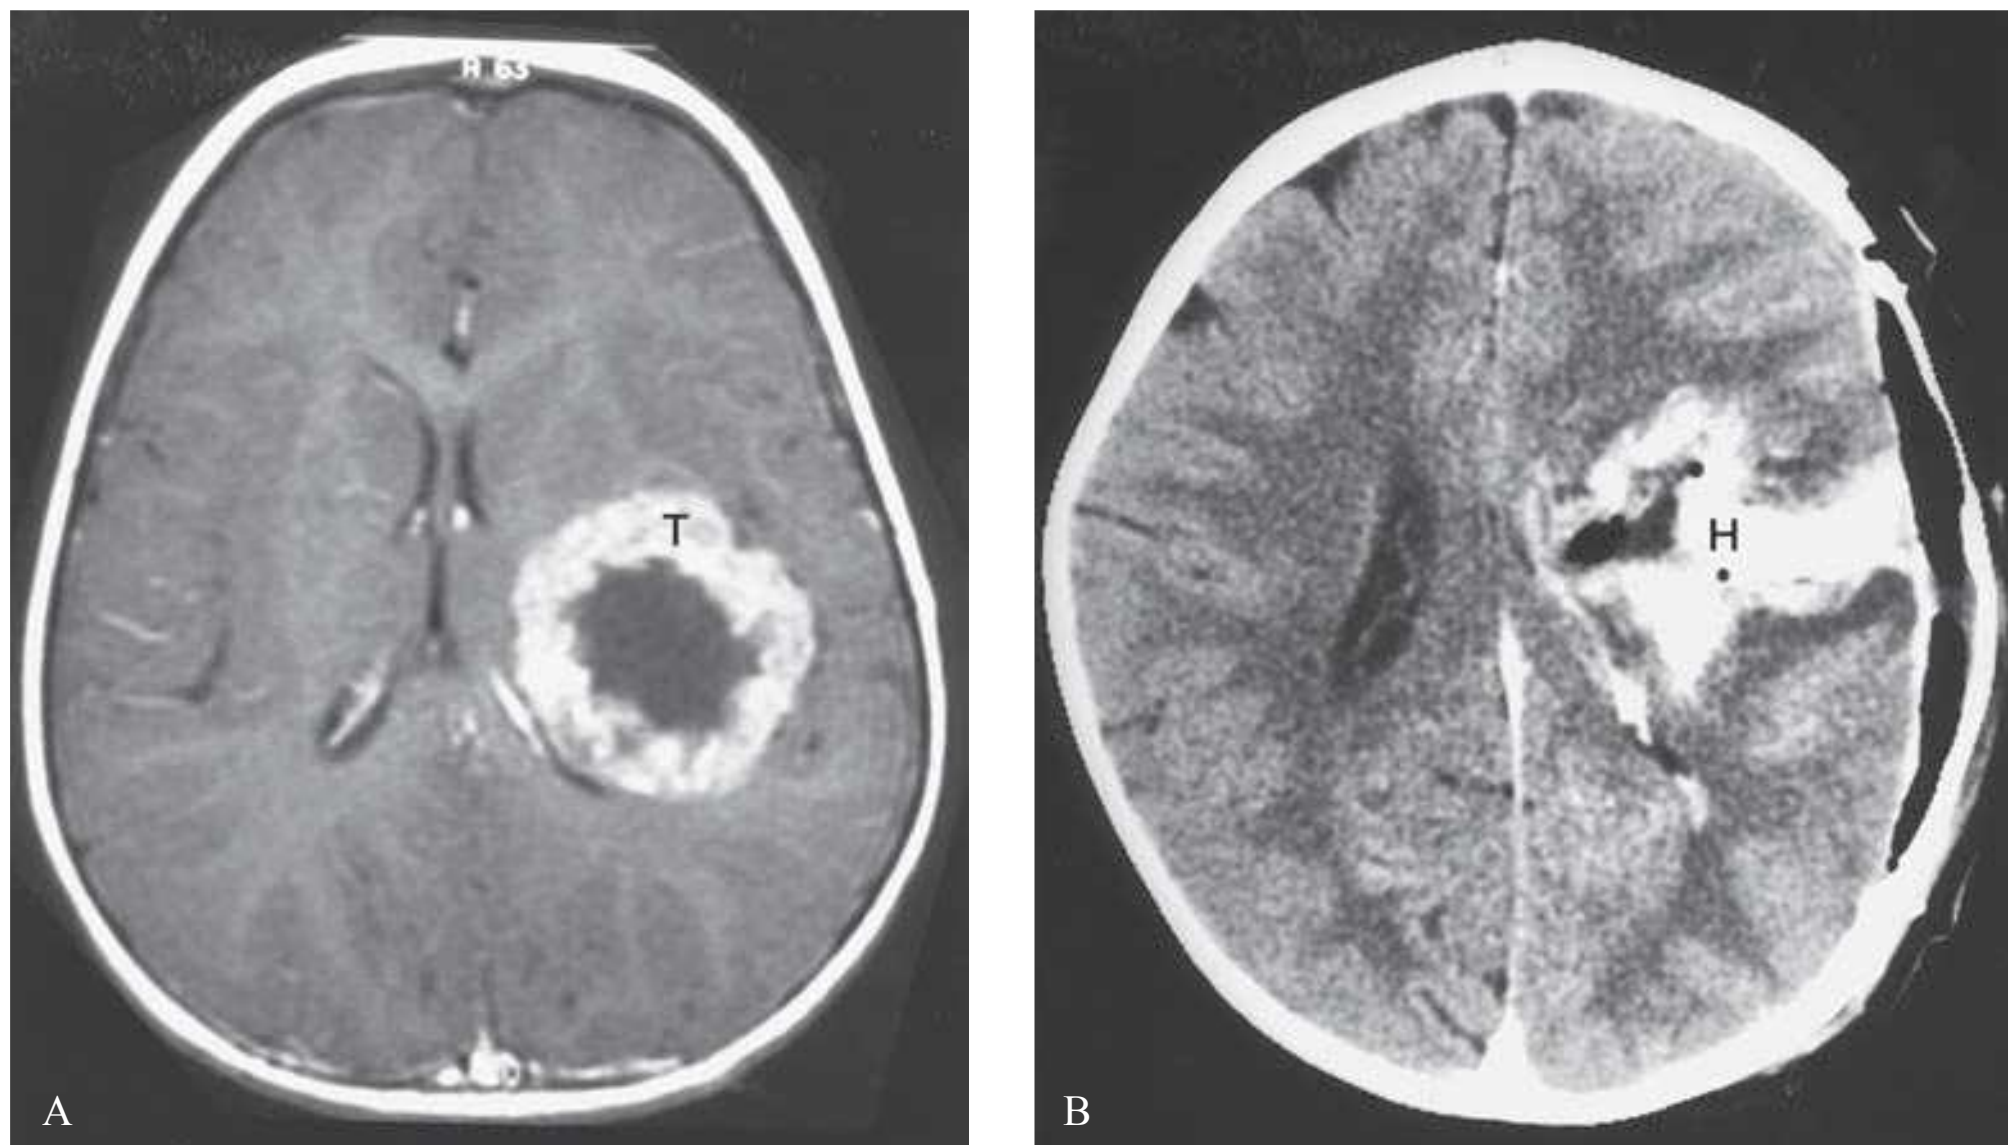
A: This magnetic resonance imaging on a 2-year-old boy shows a large enhancing mass (T) in the left temporoparietal area. B: Immediately following surgery to remove the rhabdoid neuroepithelial tumor, the patient had sustained hypertension and awakened slowly from her anesthesia with a mild right hemiparesis. This computed tomography scan shows hemorrhage (H) in the tumor bed. With blood pressure control and observation, the patient recovered to a normal level of consciousness with resolution of her hemiparesis over several days.
